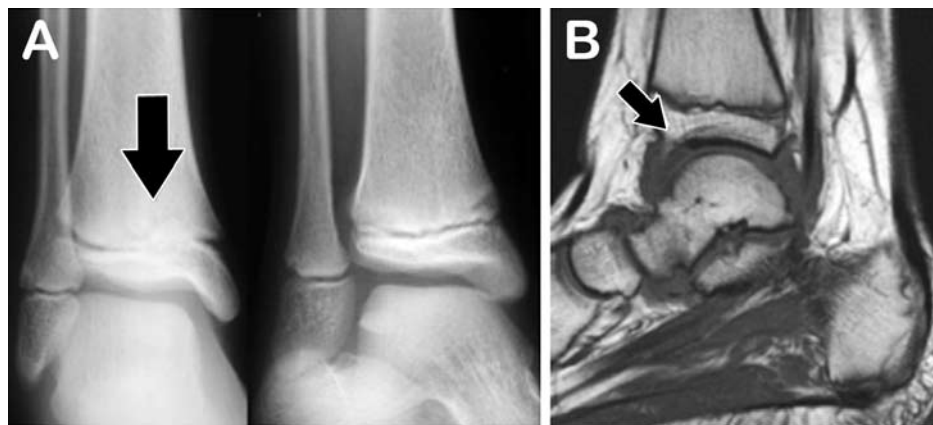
An MRI scan showing A) premature closure of tibial physis. B) A chronic epiphyseal injury with signs of premature closure.
